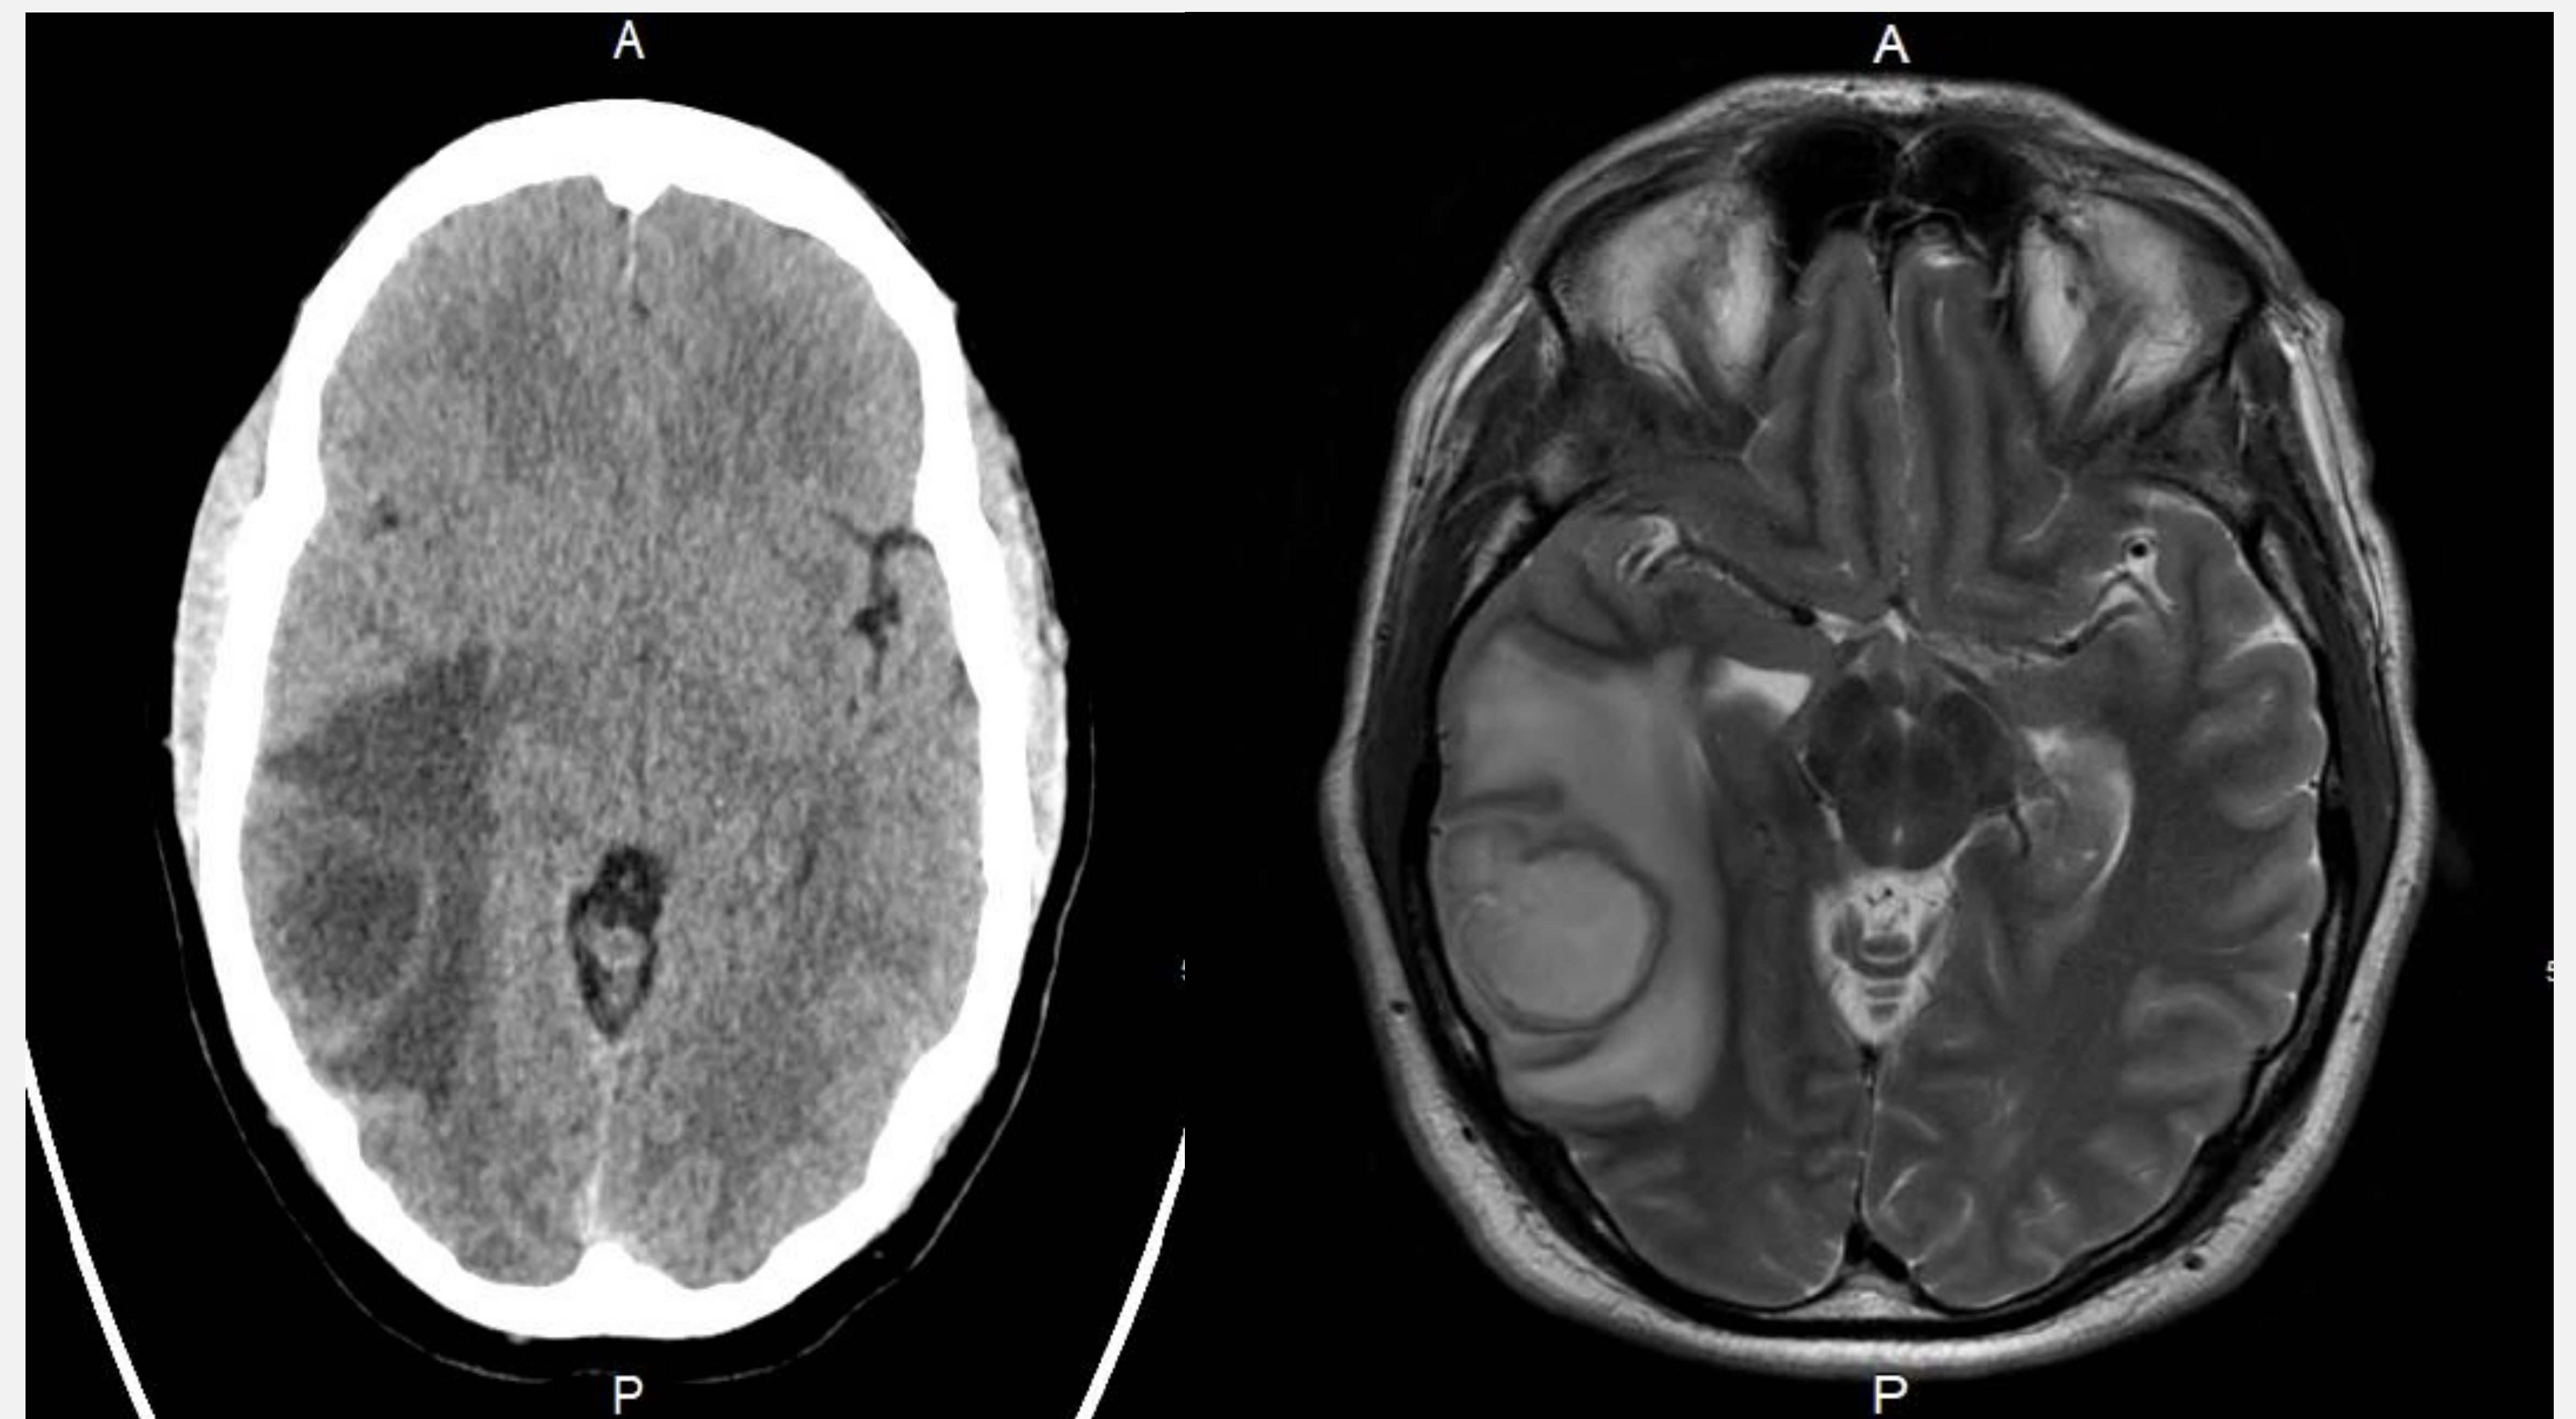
A head CT without IV contrast was performed at this point which revealed a posterior temporal necrotic mass with large surrounding edema, concerning for primary malignancy, metastatic disease, or infection. MRI with and without contrast of the brain was performed which better characterized the lesion as a 3.4 cm rim enhancing lesion, likely a cerebral abscess.
